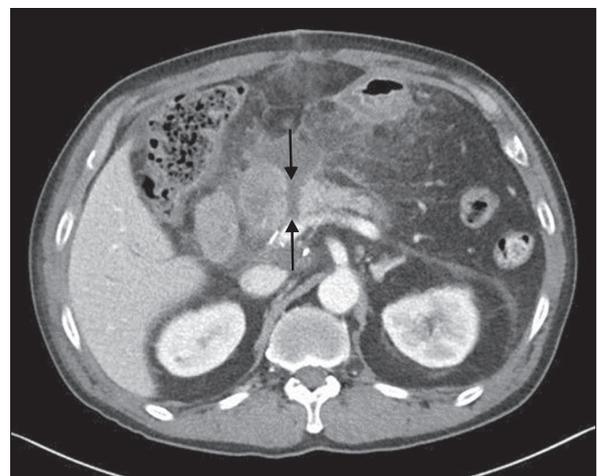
Axial computed tomography image taken after the index operation. Disrupted pancreaticojejunostomy with peripancreatic fluid collection and an associated "gap" (arrows) between the jejunum and the remnant pancreas margin is visible.
